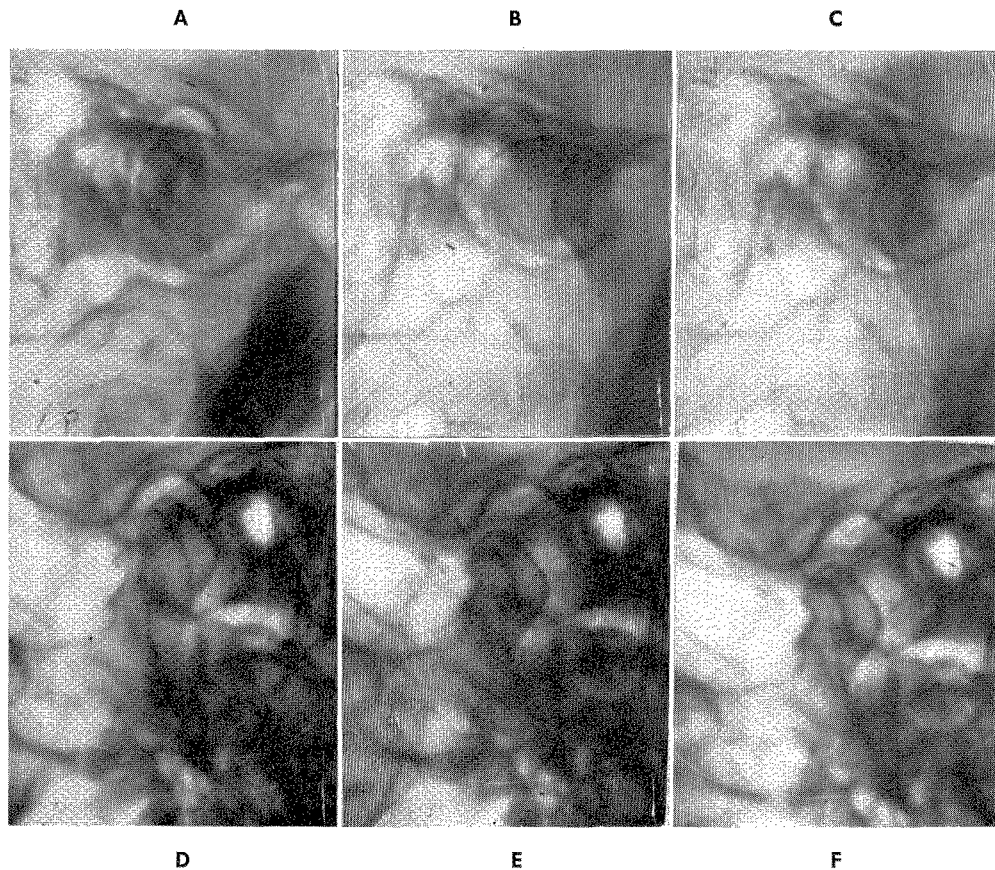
Roentgenograms of the temporomandibular joints showing the different positions of the condyles when the mandible is in its retruded, protruded, and forward contact positions. A, Left retrusion. B, Left protrusion. C, Left anterior position of maximum contact. D, Right retrusion. E, Right protrusion. F, Right anterior position of maximum contact.
